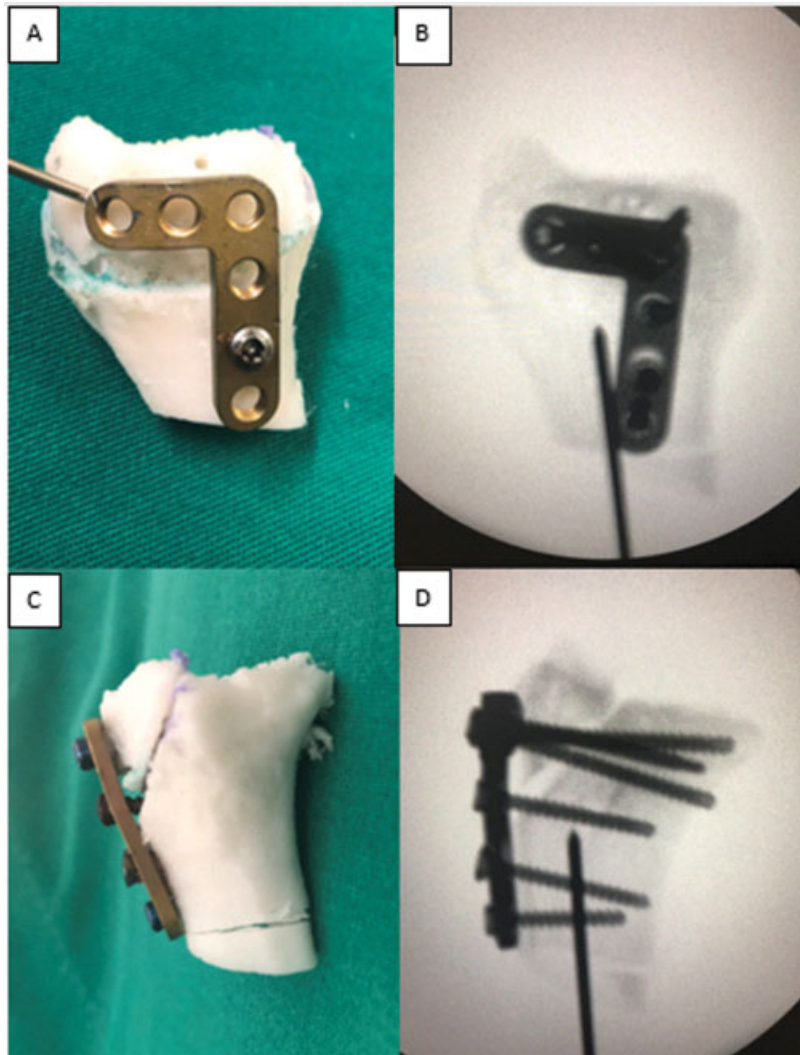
Planning and surgery with prototyping in a PLA model: guidewires placement for osteotomy in model (A, B) and fluoroscopic control of model osteotomy (C, D), prototyping after corrective osteotomy and dorsal plate fixation (E, F). Postoperative follow-up radiographies (G, H).
